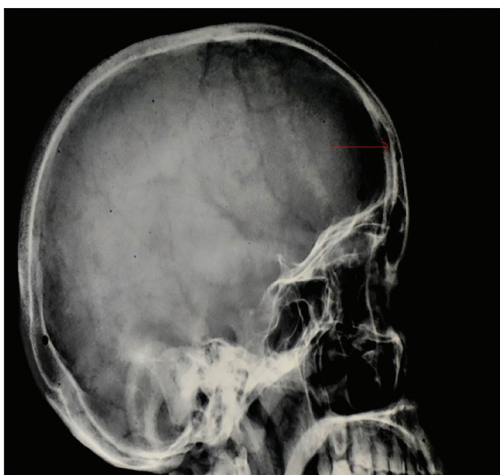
Radiography of skull showing a lytic lesion (red arrow) in the frontal bone.
